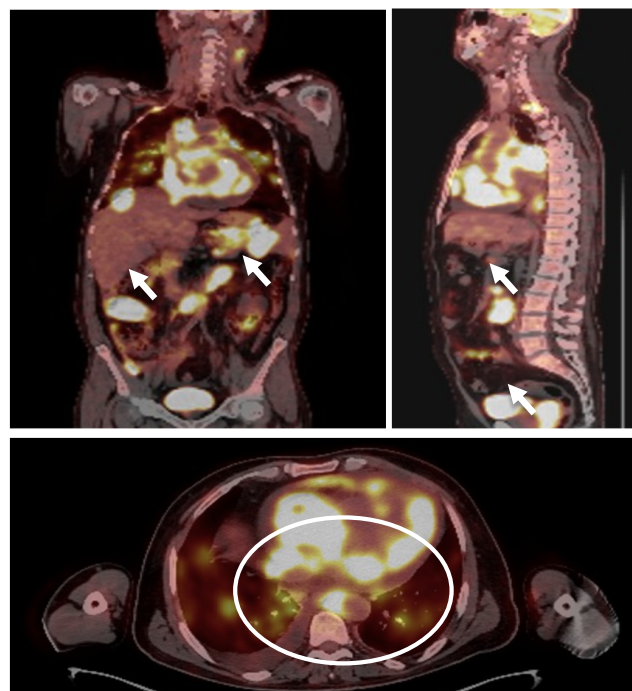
FDG PET/CT images in multiple planes demonstrate cardiac, nodal, and extranodal involvement.
